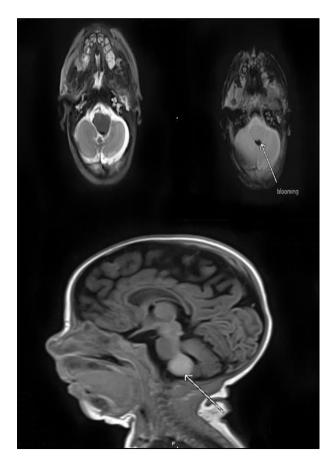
Magnetic resonance images showing an exophytic space occupying lesion in the medulla oblongata slightly towards the left side
